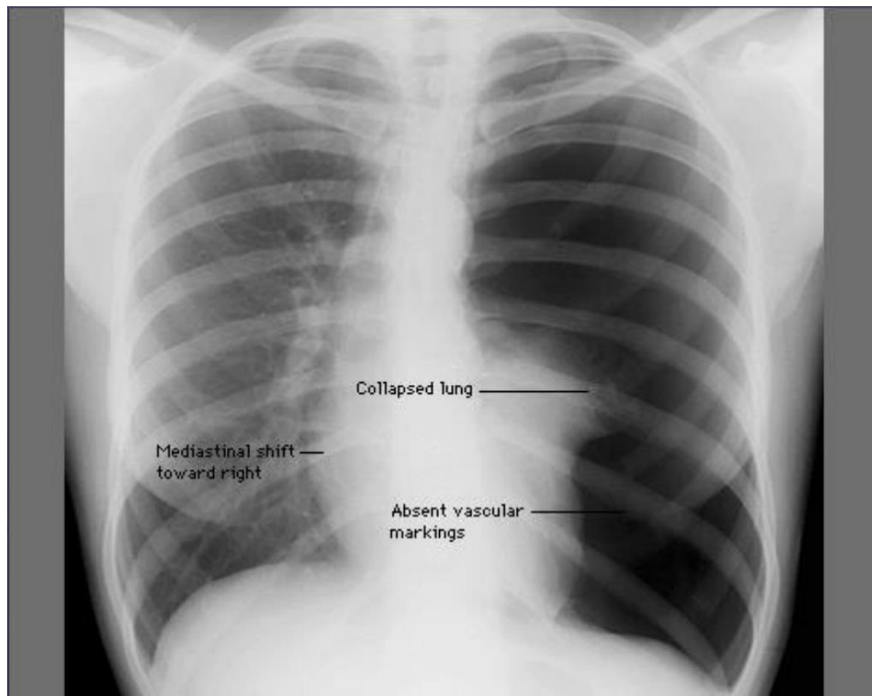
Chest X-ray with pneumothorax
